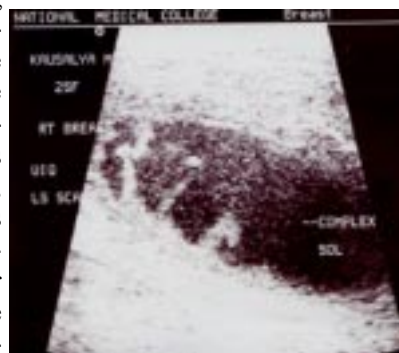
Ultrasound Picture of a complex Abscess
